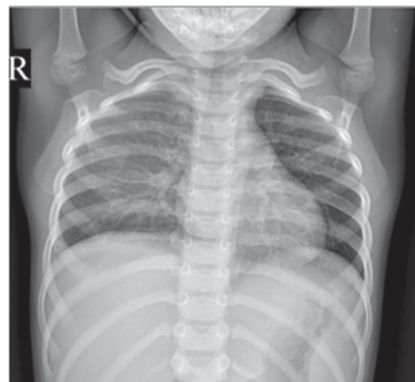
X-ray chest: Right pleural fluid. Increased opacity of right hemithorax
